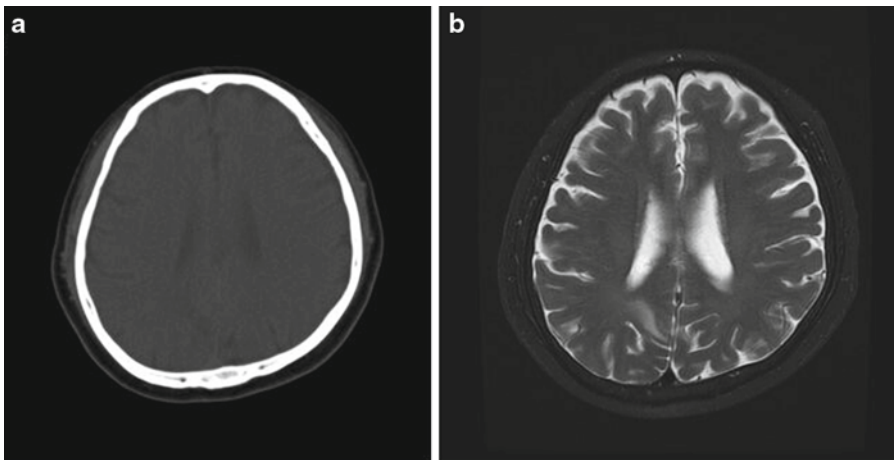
Comparison of x-ray CT (a) and MRI (b) in the brain
